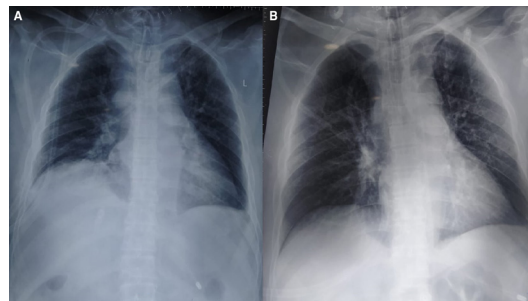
Chest X-ray images on (A) day 6 showing blunting of bilateral costophrenic angle suggestive of pleural effusion and (B) day 20 showing resolution of earlier findings.
